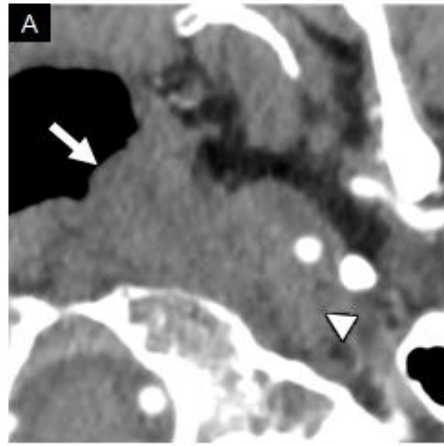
72-year-old man with poorly differentiated nonkeratinizing squamous cell carcinoma of the nasopharynx (HPV-related). Axial temporal bone NECT (A) shows osseous destruction along the left skull base (white arrows). Axial T1WI C+ FS MRI (B) demonstrates a left nasopharyngeal mass (black arrow) with invasion of the left prevertebral soft tissues (black arrowhead) and extension along the skull base. Coronal T1WI C+ FS MRI (C) better delineates the skull base and intracranial extension (black arrowhead) of the left nasopharyngeal mass (black arrow). Axial 18F-FDG PET/CT (D) shows the left nasopharyngeal mass to be markedly FDG avid (black arrow). Coronal 18F-FDG PET/CT (E) shows the intracranial extension (black arrowhead) of the left nasopharyngeal mass (black arrow), but is markedly limited in differentiating FDG avid tumor from normal FDG avidity in the brain.
